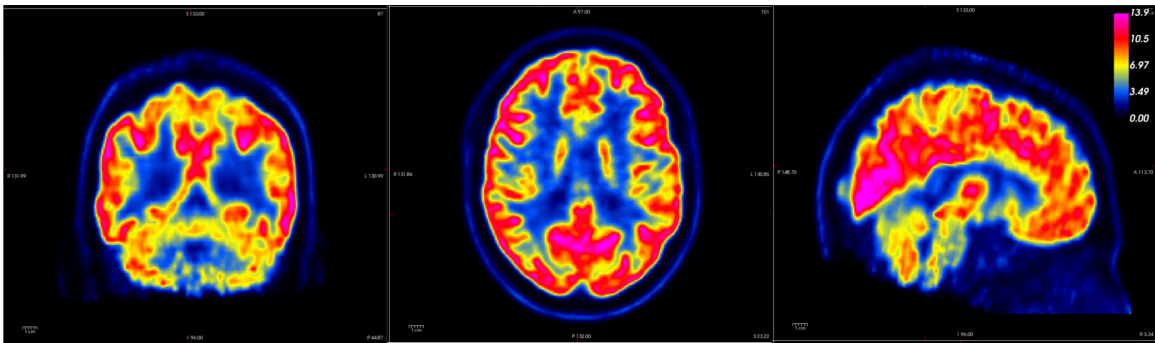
^{18}F -FDG Positron emission tomography scan of a healthy brain
